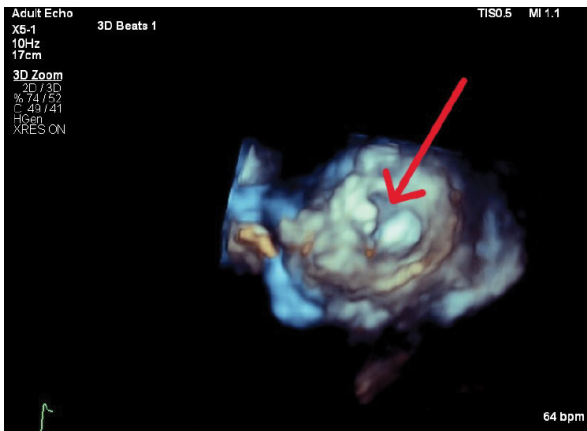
3D transthoracic echocardiography, short axis view of the left ventricle. A vegetation on the posterior leaflet of the mitral valve and leaflet perforation (arrow) can be seen
